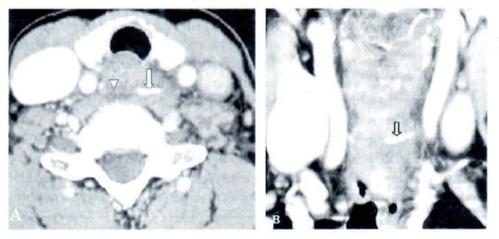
Axial (A) and coronal (B) computed tomography scan. The fish bone (arrow) is clearly seen outside the esophagus in the left prevertebral space associated with soft tissue edema.(arrowhead)
